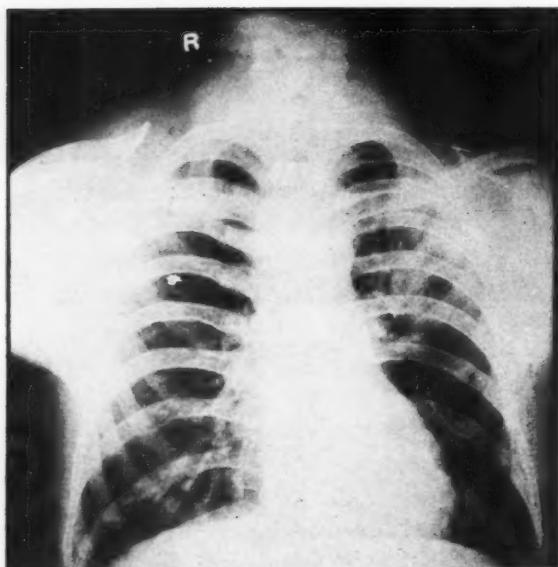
Admission roentgenogram of twenty-six year old white male.
